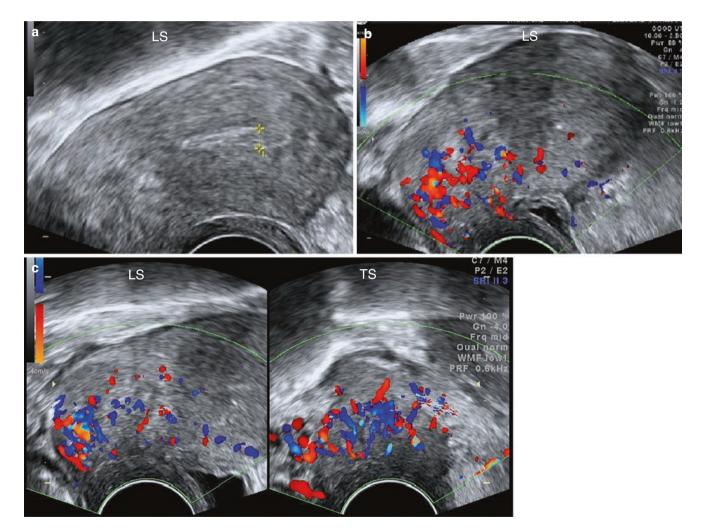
Squamous cell carcinoma extending into the lower uterine corpus. (a) Greyscale image showing a bulky, heterogeneous cervix with the margins of the tumour difficult to delineate. (b) Suspicious area that was seen on greyscale shows increased flow on Doppler. (c) Heterogeneous cervix with the tumour margins and cervical canal not well delineated. Doppler helped identify the neoplastic tissue
